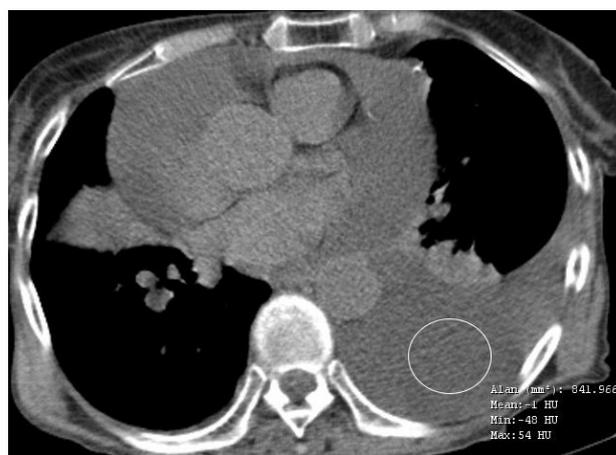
Unenhanced axial chest CT scan of an 80-year-old female diagnosed as congestive cardiac failure presenting with left transudative pleural effusion; CT attenuation value is -1 HU.
